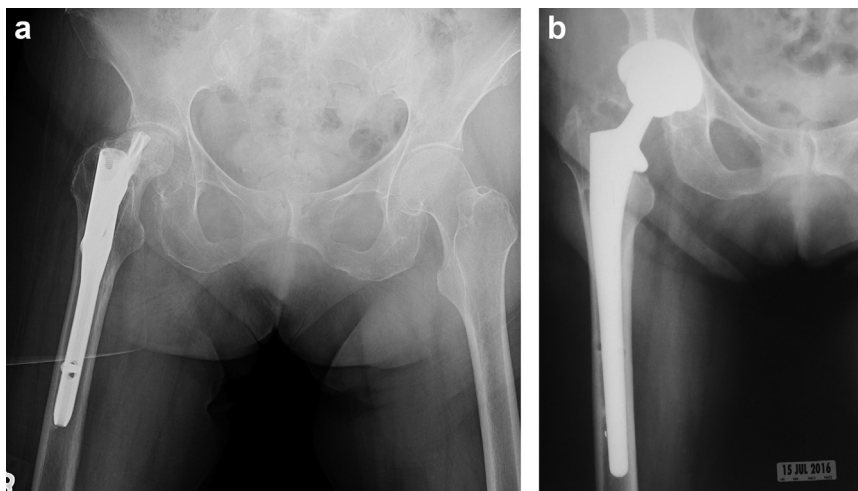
(a) Preoperative cephalomedullary nail in place with femoral head collapse, proud proximal device, and massive external rotation (anteroposterior radiograph). (b) Postoperative radiograph after conversion to total hip arthroplasty (anteroposterior radiograph).
